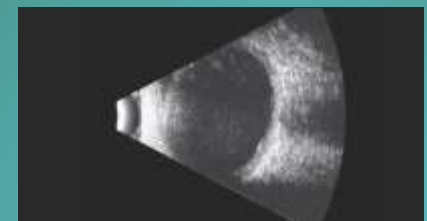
Ultrasonography image of a case of rebleed in a vitrectomized eye
